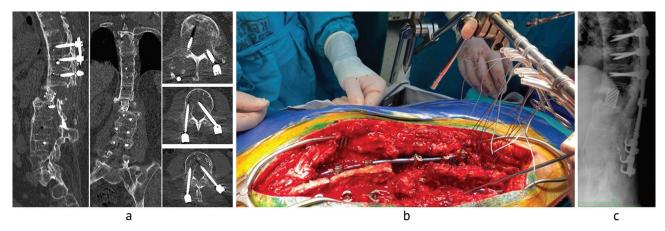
Radiological and intraoperative signs of unstable metal construct and stages of the primary revision intervention seen on: (a) sagittal, frontal and axial CT scans on the 12^{th} day after the primary operation showing translation of the thoracic spine, migration of the interbody implant, loosening of the screws in the lumbar spine with large (> 3 mm) zones of osteolysis in the L_2 , L_3 , L_4 vertebrae; (b) external fixator assembled of a Thompson retractor sleeve and lavsan threads passed through the spinous processes and fixed to the frame; (c) postoperative radiograph in the sagittal plane
